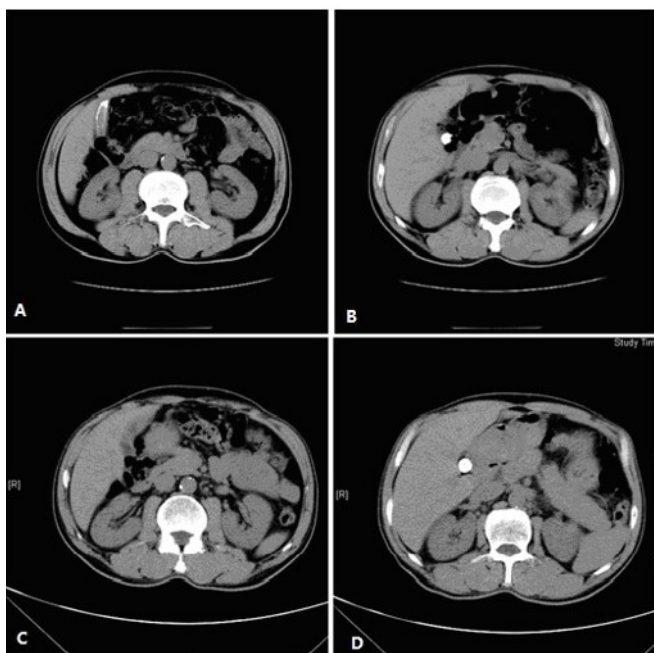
The CT scan of upper abdomen. A. the wall of gallbladder was thickened and calcified. B. the diameter of gallbladder stone was 1.46 cm. C. the calcified wall of gallbladder was disappeared. D. the diameter of gallbladder stone was 1.63 cm.
